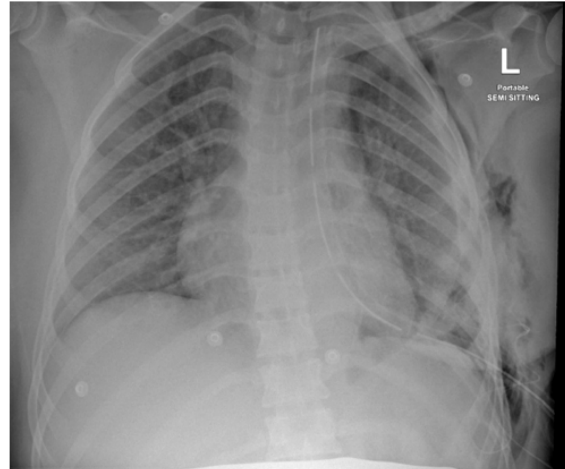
A chest X-ray revealed left-sided drainage tube catheter with its tip projecting over the apical region. Small effusion and surgical emphysema noted on left side. Mild atelectatic changes are seen in the left lung base
